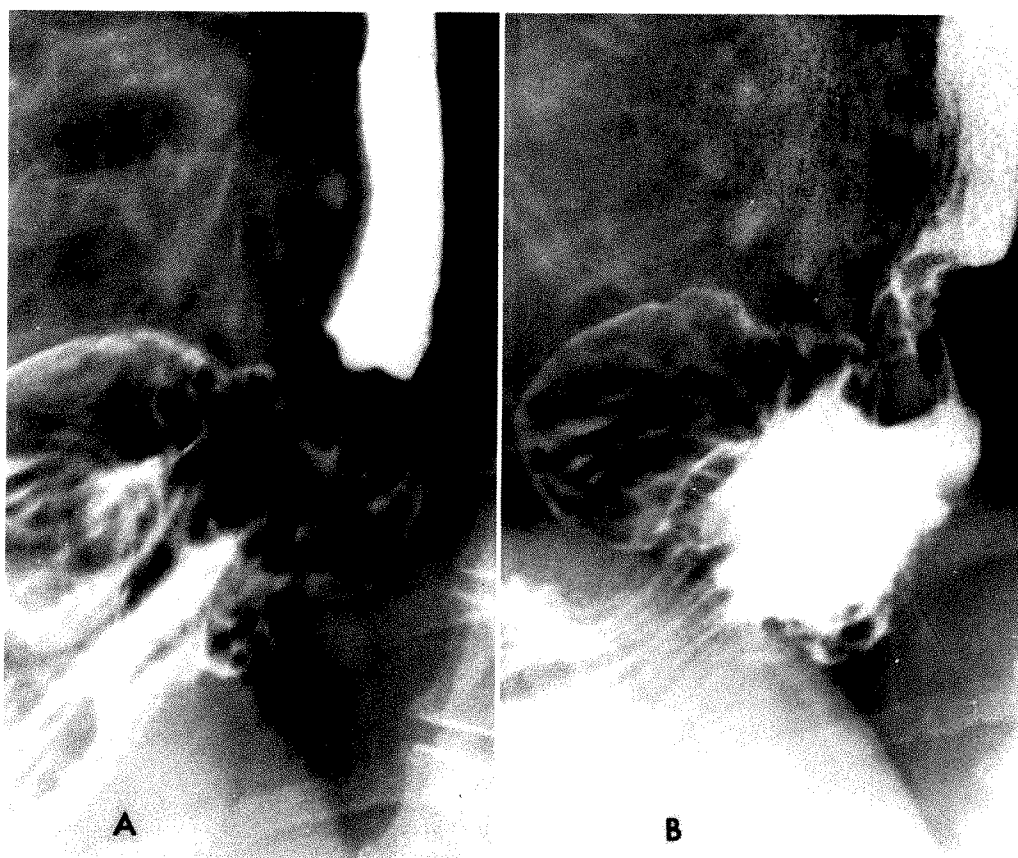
(A) Roentgenogram shows barium bolus about to enter region of hernia. (B) Roentgenogram made 2 seconds later shows that the barium bolus has obviously entered the hernia and is beginning to spread between the gastric folds. The esophagogastric junction is, therefore, obviously *above* the diaphragm, and the hernia is of the sliding type.
